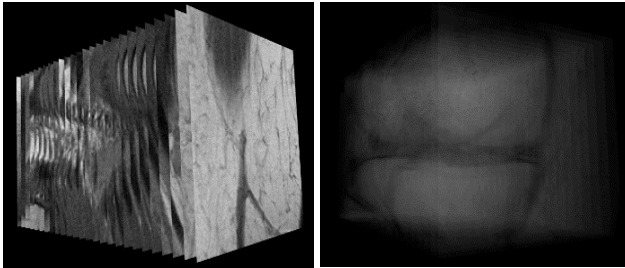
2-D array of processed ROI of a MR image (right). 3-D projection of the ROI data (left).
